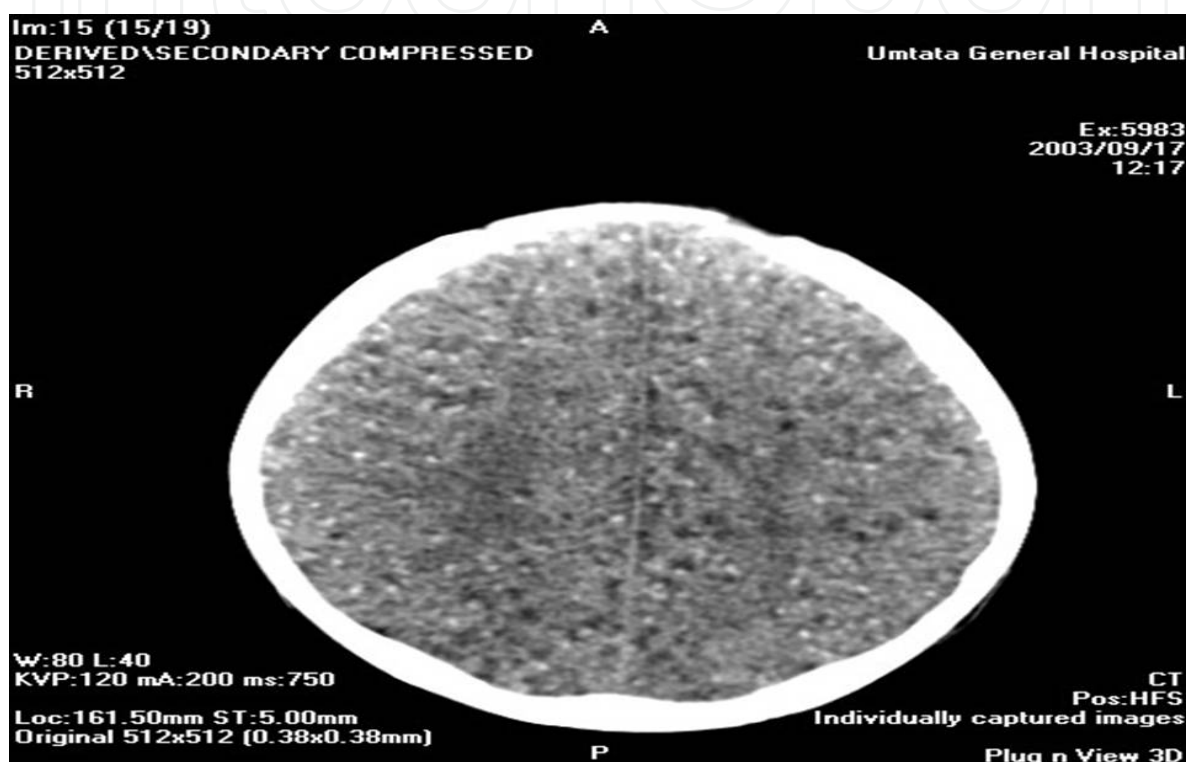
CT scan of the brain showing massive neurocysticercosis.
